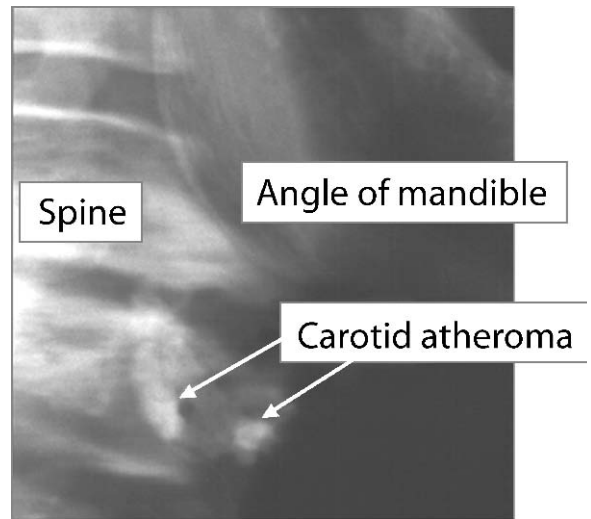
Detail from panoramic radiograph
